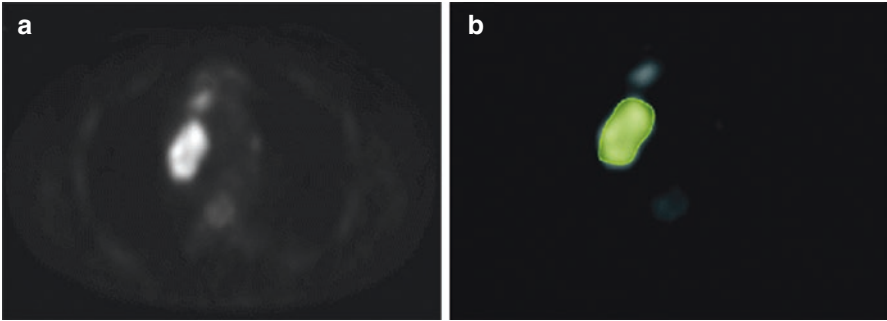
(a, b) Axial positron emission tomography (PET) scan of the thorax shows fluoro-deoxy-glucose (FDG) avid uptake by mediastinal lymph nodes in a case of lymphoma (*green*)
